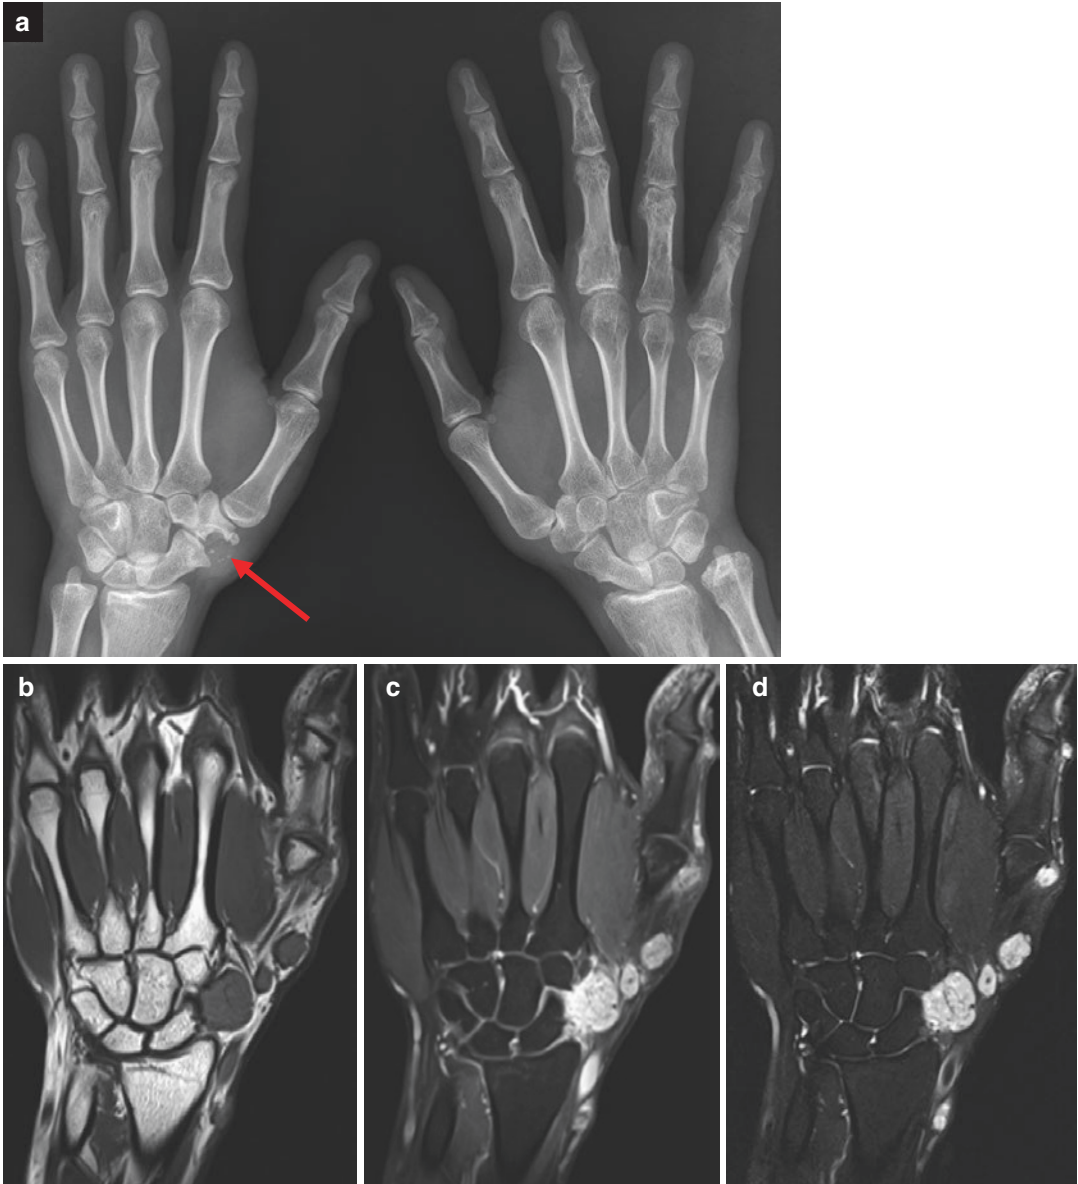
Maffucci syndrome. AP radiograph of both hands (a) shows multiple enchondromas in the left 3rd–5th fingers and the left distal radius and ulna. There are multiple soft tissue masses in the right wrist and thumb, one (arrow) of which has multiple calcific foci and erodes the trapezium and scaphoid. Coronal T1WI (b), FS T2WI
